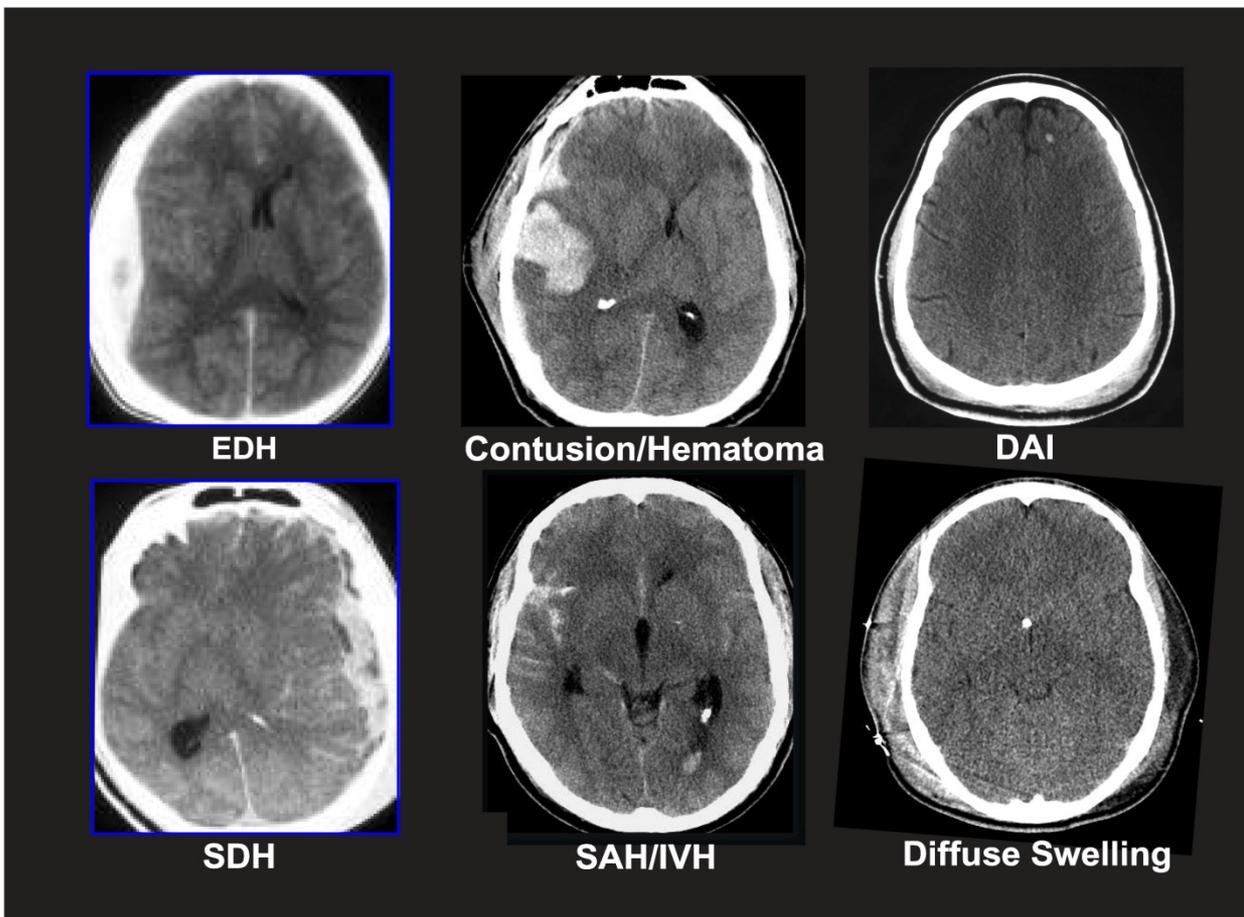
Heterogeneity of severe traumatic brain injury (TBI). Computed tomography (CT) scans of six different patients with severe TBI, defined as a Glasgow Coma Scale score of <8, highlighting the significant heterogeneity of pathological findings. CT scans represent patients with epidural hematomas (EDH), contusions and parenchymal hematomas (Contusion/Hematoma), diffuse axonal injury (DAI), subdural hematoma (SDH), subarachnoid hemorrhage and intraventricular hemorrhage (SAH/IVH), and diffuse brain swelling (Diffuse Swelling).
